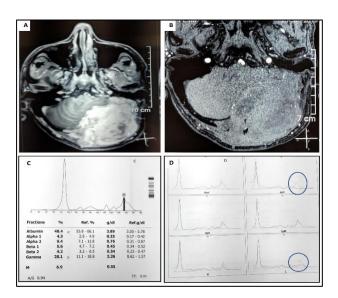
Magnetic resonance imaging (MRI) of the brain with contrast showing extra-axial lobulated mass, heterogeneously hyperintense on T2/FLAIR (A) and isointense on T1 WI(B). Serum electrophoresis revealed M band in gamma region (0.55g/dl)(C), immunofixation showing IgG lambda type of M-band in gamma region(D).
